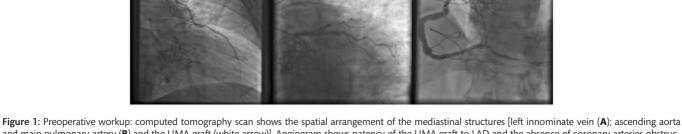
Preoperative workup: computed tomography scan shows the spatial arrangement of the mediastinal structures [left innominate vein (A); ascending aorta and main pulmonary artery (B) and the LIMA graft (white arrow)]. Angiogram shows patency of the LIMA graft to LAD and the absence of coronary arteries obstruction: LIMA-LAD (C); left circumflex (D), RCA (E). LIMA: left internal mammary artery; LAD: left anterior descending artery; RCA: right coronary artery.
